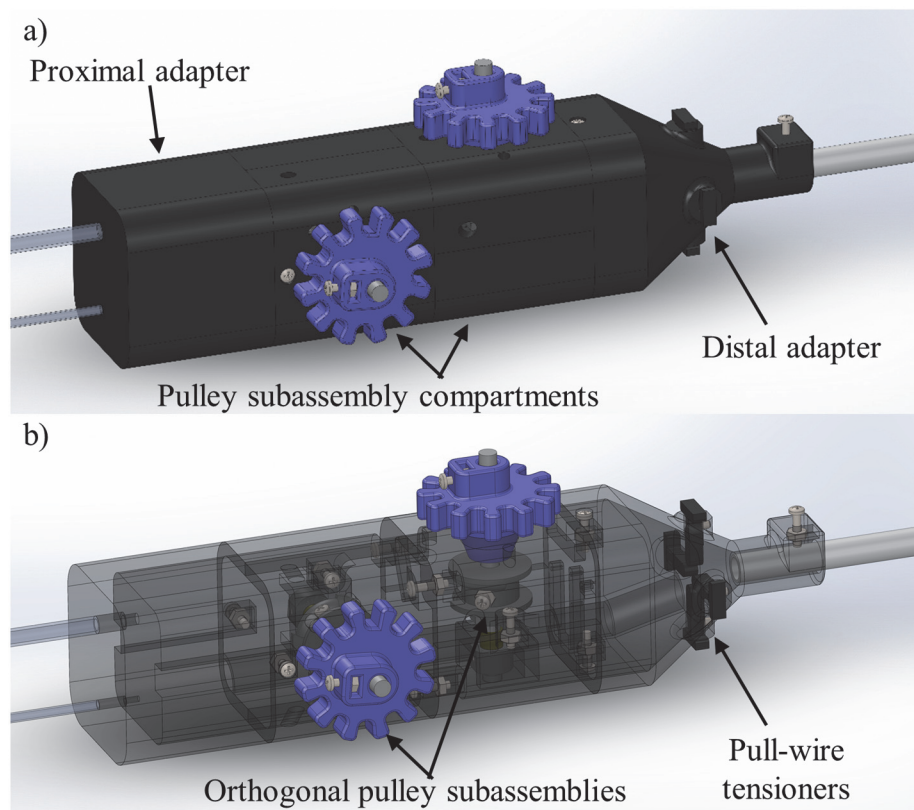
Control handle assembly, containing four modular compartments that appropriately route power/flow lines from the ultrasound applicator to external connectors and pull-wires to their respective pulley assembly. Housing body is shown in (a) opaque and (c) transparent display states.
